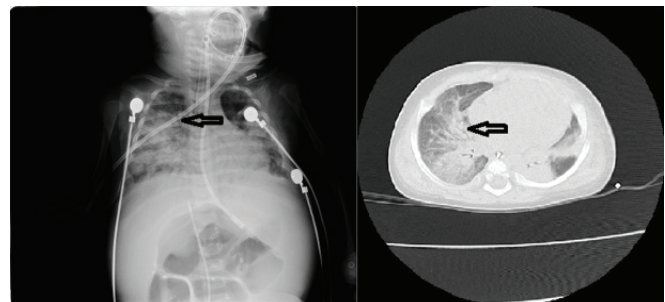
Lobar/segmental consolidations are detected on X-ray (right) and CT (left) of the lungs. Air-bronchograms are seen (arrows)
